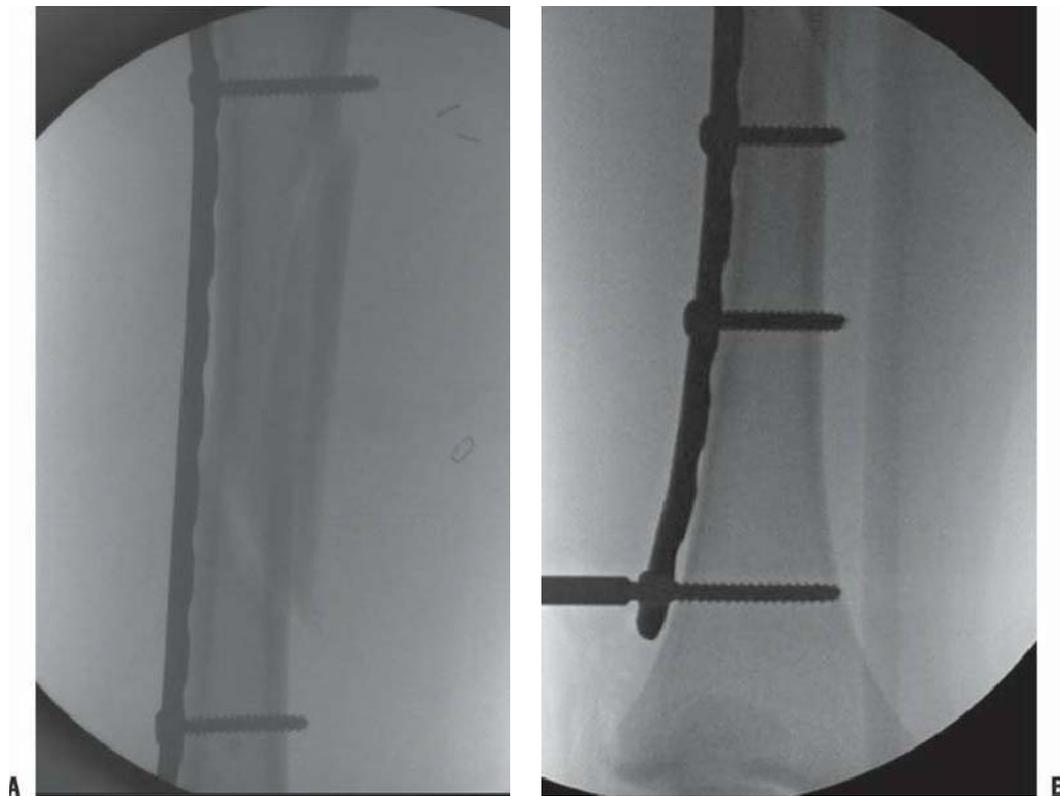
The second screw is placed on the other margin of the fracture as the fracture is bridged. A: The remaining screws are spread as far apart as possible. B: Once all the screws are placed, the sutures are cut. A soft dressing is applied. Patients are allowed to be touchdown weight bearing until about 6 weeks when early callus is visualized on radiographs. At that time, weight bearing can be progressed as tolerated.
